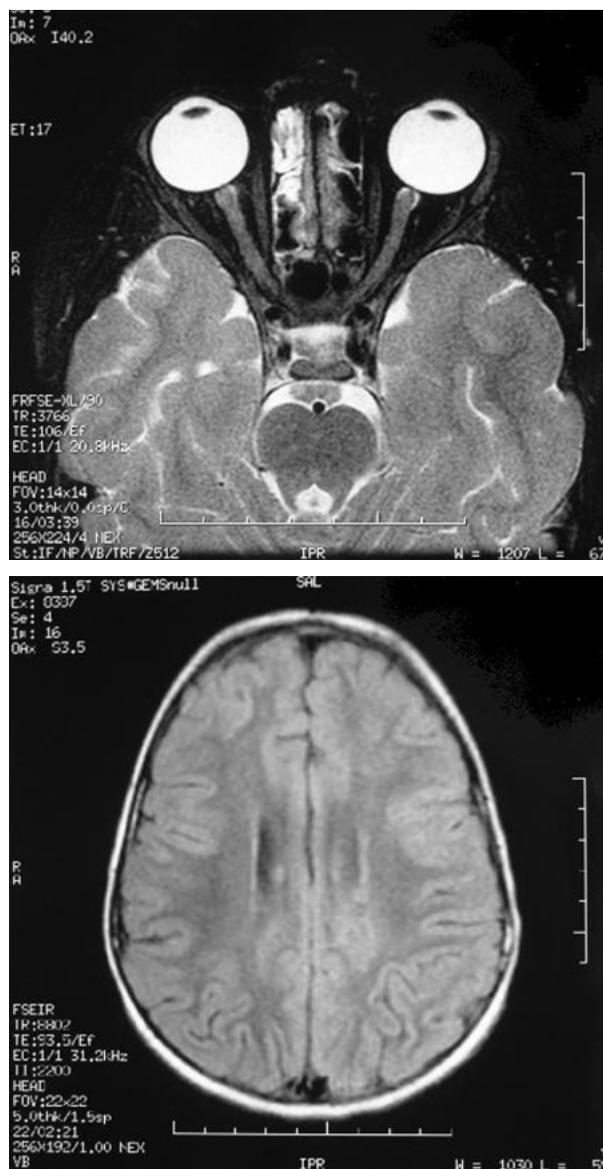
Cranial magnetic resonance images (axial projections) of the case patient obtained 1 week after completion of oral steroid therapy. Near complete resolution of inflammatory demyelination changes is demonstrated in both images, including the prechiasmatic optic pathway (upper panel).
